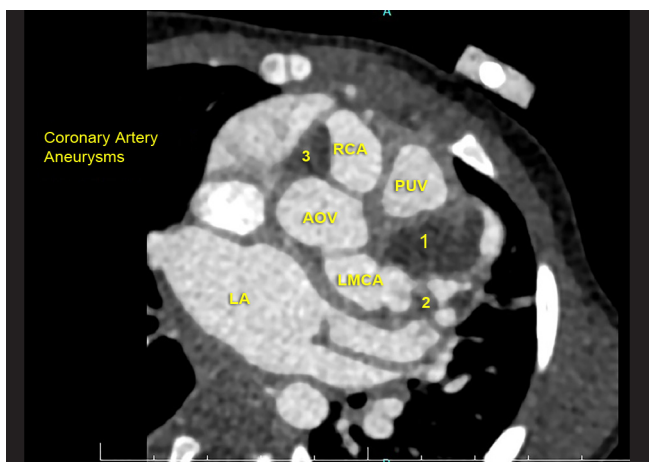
Huge aneurysm in Right coronary artery and left main coronary artery in heart CT angiography and the numbers (1, 2, and 3) represent the number of thrombosis
